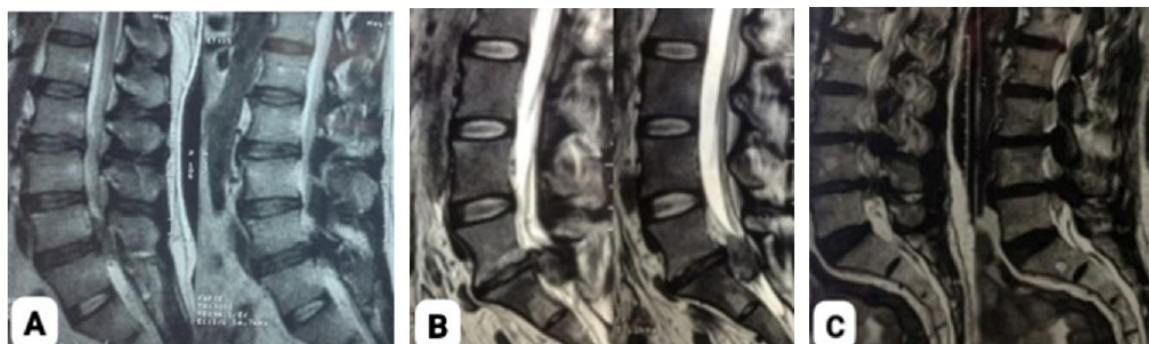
Different MRI T2 -weighted images, sagittal views showing different pathological levels for CES patients, (A): Shows L4-5 disc prolapse, (B): Shows L5- S1 disc prolapse with caudal migration, (C): Shows multiple levels of lumbar disc prolapse associated with lumbar canal stenosis.
